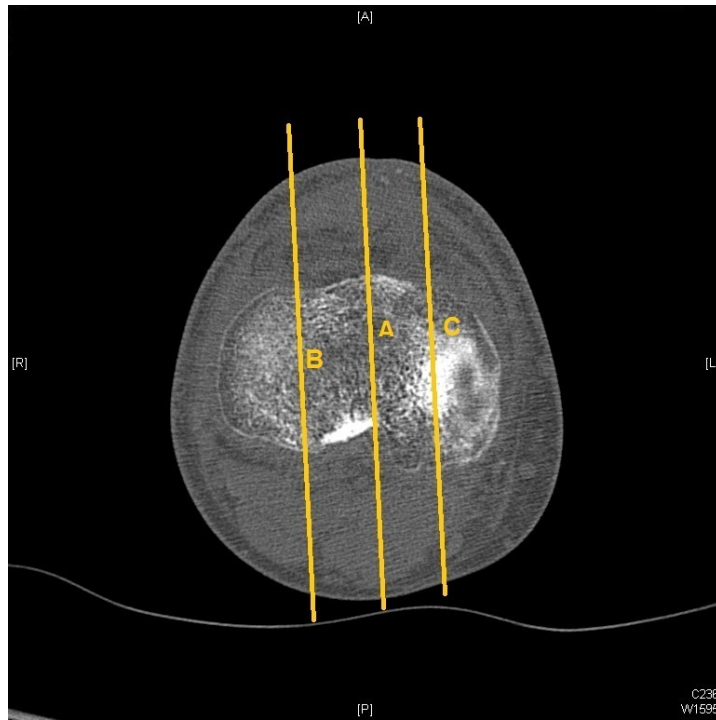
Three CT axial cuts of the tibia at superior joint line were taken to select the corresponding midsagittal (A), the mid-medial sagittal (B), and the mid-lateral sagittal images (C).
